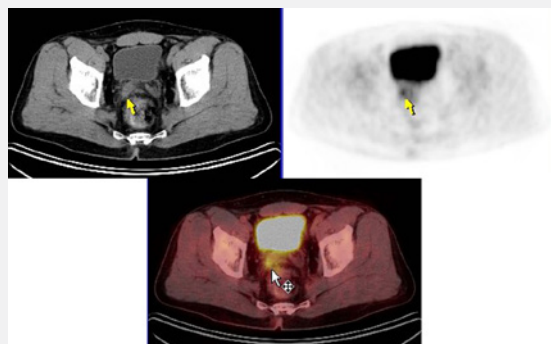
PET/CT images of right seminal vesicle metastasis.
